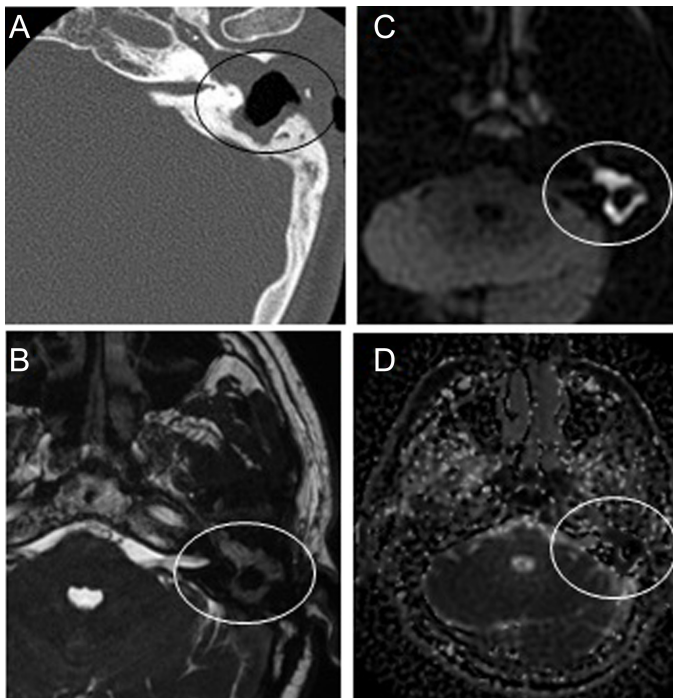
(A) Axial CT image, (B) T2-weighted thin-sliced image shows secretions in the same form as C, D. (C, D) Diffusion restriction (rings). CT, computed tomography.
